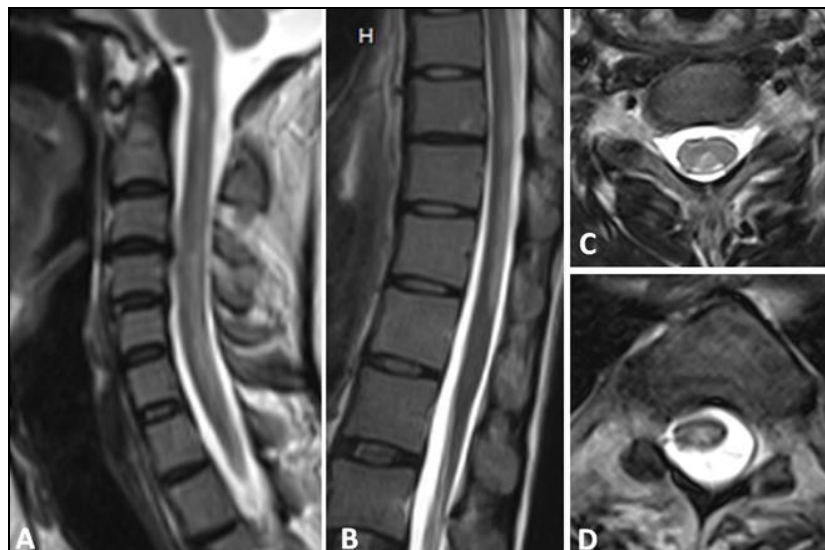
Subacute combined degeneration of the cord. T2 Sagittal MRI cervical spine image (A) shows long segment hyperintensity involving the cervical cord. Axial T2W images (C) show bilateral symmetric T2 hyperintensities in dorsal columns of spinal cord resembling an ‘inverted V’ pattern. T2 Sagittal MRI thoracolumbar spine image (B) shows long segment hyperintensity involving the lower dorsal spinal cord. Axial T2W images (D) show bilateral symmetric T2 high signal intensities within the dorsal columns of thoracic spinal cord resembling an ‘inverted V’ pattern.
